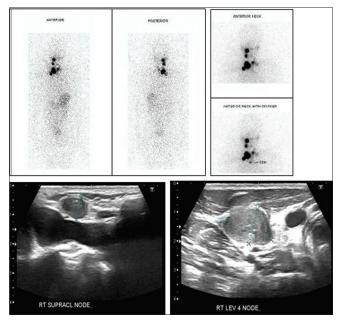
A 23-year-old male with biopsy-proven papillary thyroid carcinoma and posttotal thyroidectomy. His unstimulated serum thyroglobulin value was 19.14 ng/ml. Stimulated serum thyroglobulin levels obtained after 6 months were 1380 ng/ml. Ultrasonography neck and thyroid whole-body radioiodine scintigraphy revealed nodal recurrence
